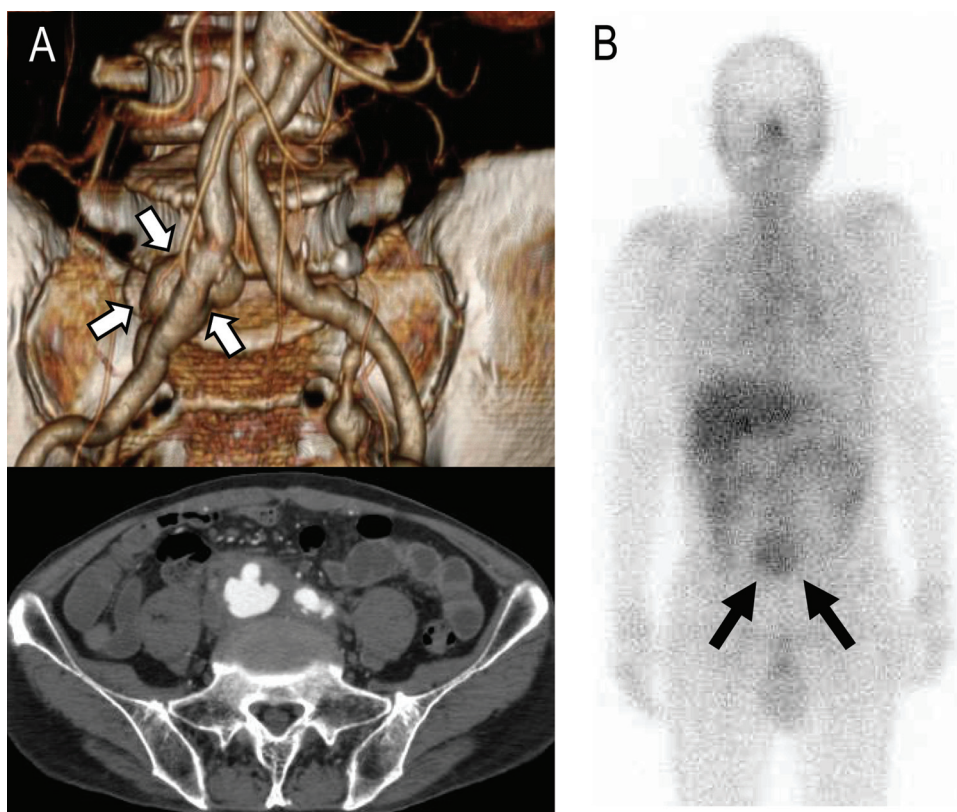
(A) Enhanced CT upon admission showing a pseudoaneurysm (arrows) at the anastomotic site of the artificial vessel and the right common iliac artery. (B) ⁶⁷Ga scintigraphy showing abnormal uptake (arrows) at the same site as the pseudoaneurysm.
